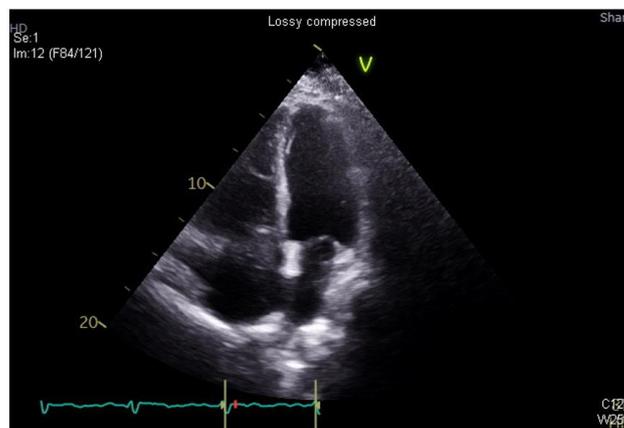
Apical four-chamber view shows intracavitary cardiac mass entering the right atrium during systole.
